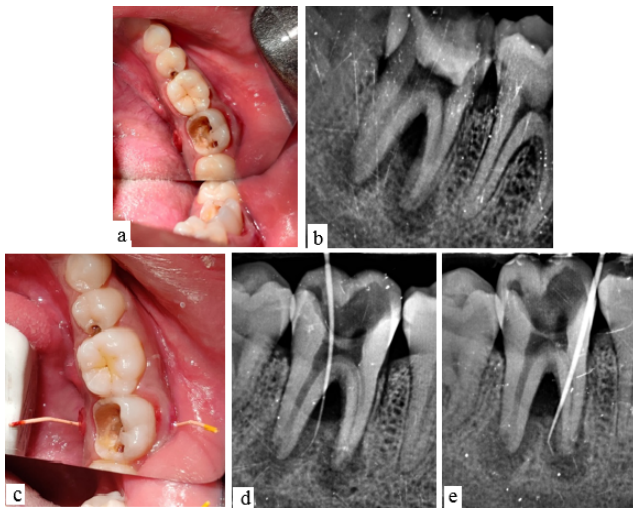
a: Showing Preoperative clinical picture of involved tooth; b: Preoperative radiograph showing large peri apical lesion involving both roots; c: Clinical image of sinus tracing with guttapercha; d-e: Radiographs of sinus tracing in both root.
